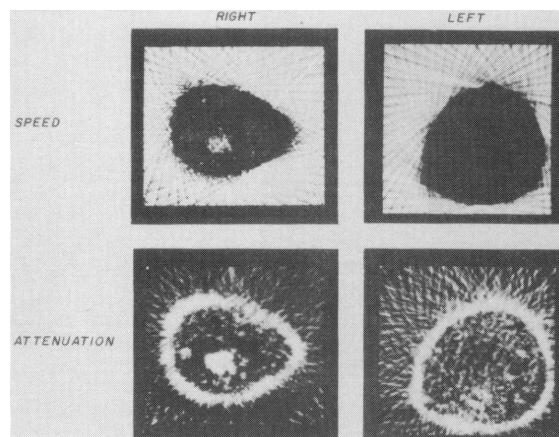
Reconstructions of speed of sound and attenuation showing scirrous carcinoma in the right breast based on ultrasound computed tomography (Greenleaf and Bahn, 1981).
